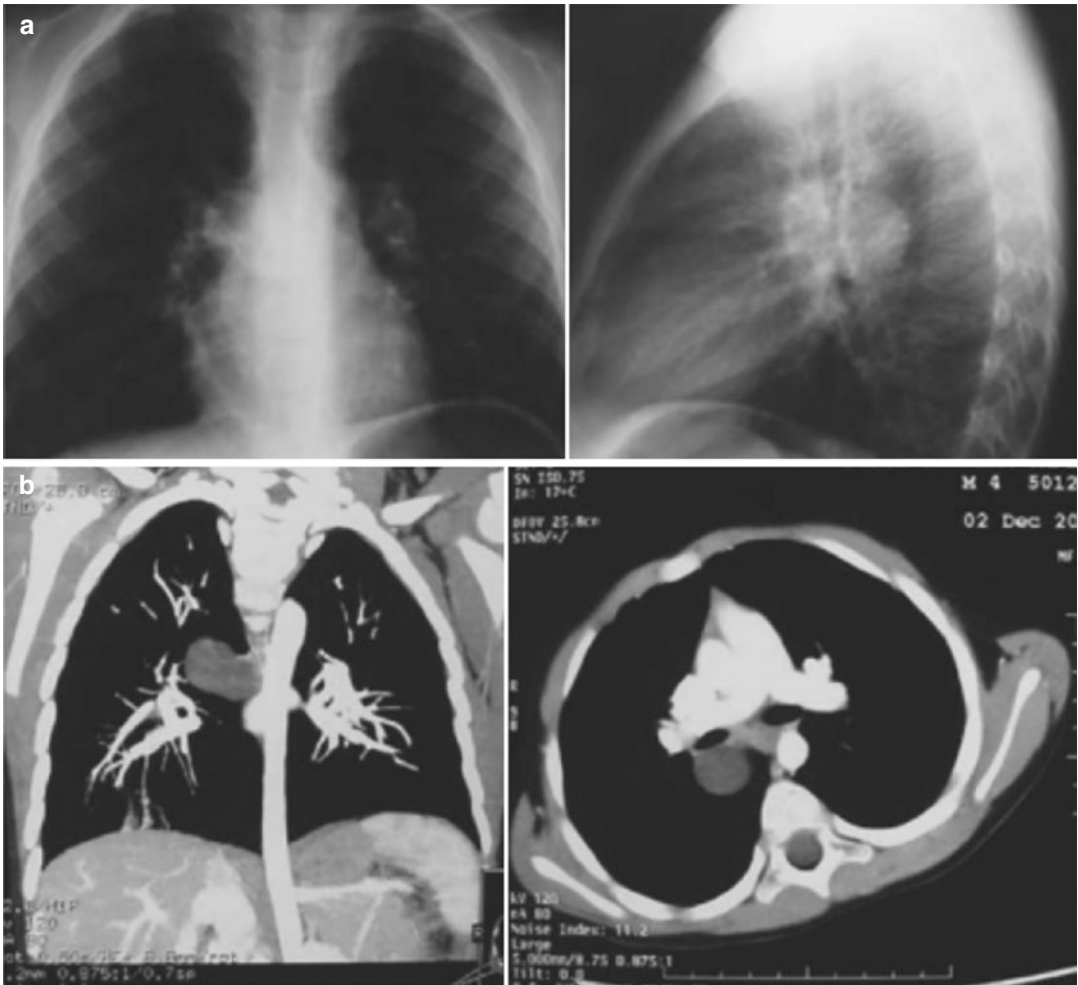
Bronchogenic cyst. (a) Anteroposterior (AP) and left chest X-ray in an adolescent shows a circumferential lesion, well delimited in the posterior mediastinum.
